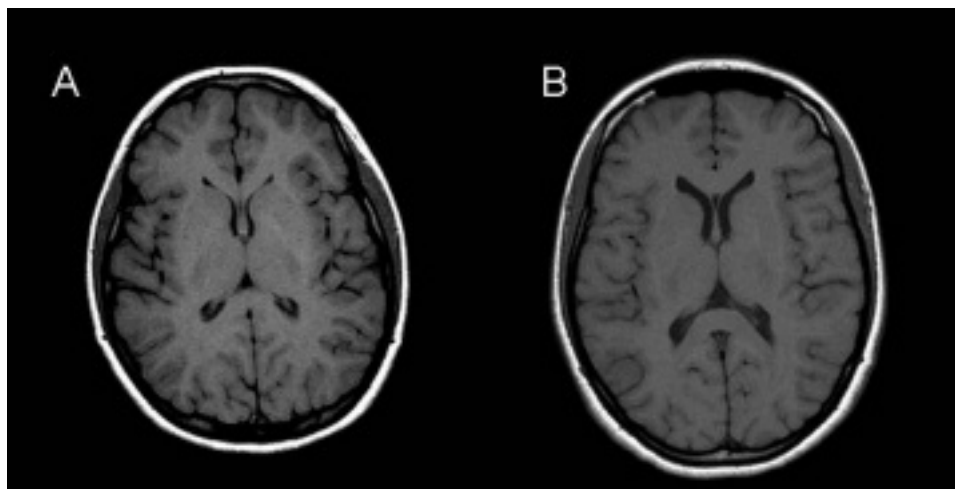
Qualitative features of mild cerebral volume loss. A. Axial T1-weighted image through the plane of the basal ganglia showing normal sulci, third ventricle, and supratentorial ventricular system in a 15.5-year-old girl with new-onset SLE and seizures. B. Slight prominence to the supratentorial ventricular system. Mild increase in size of lateral ventricles, cerebral sulci preserved in a 17-year-old girl with new-onset SLE and behavior changes.
